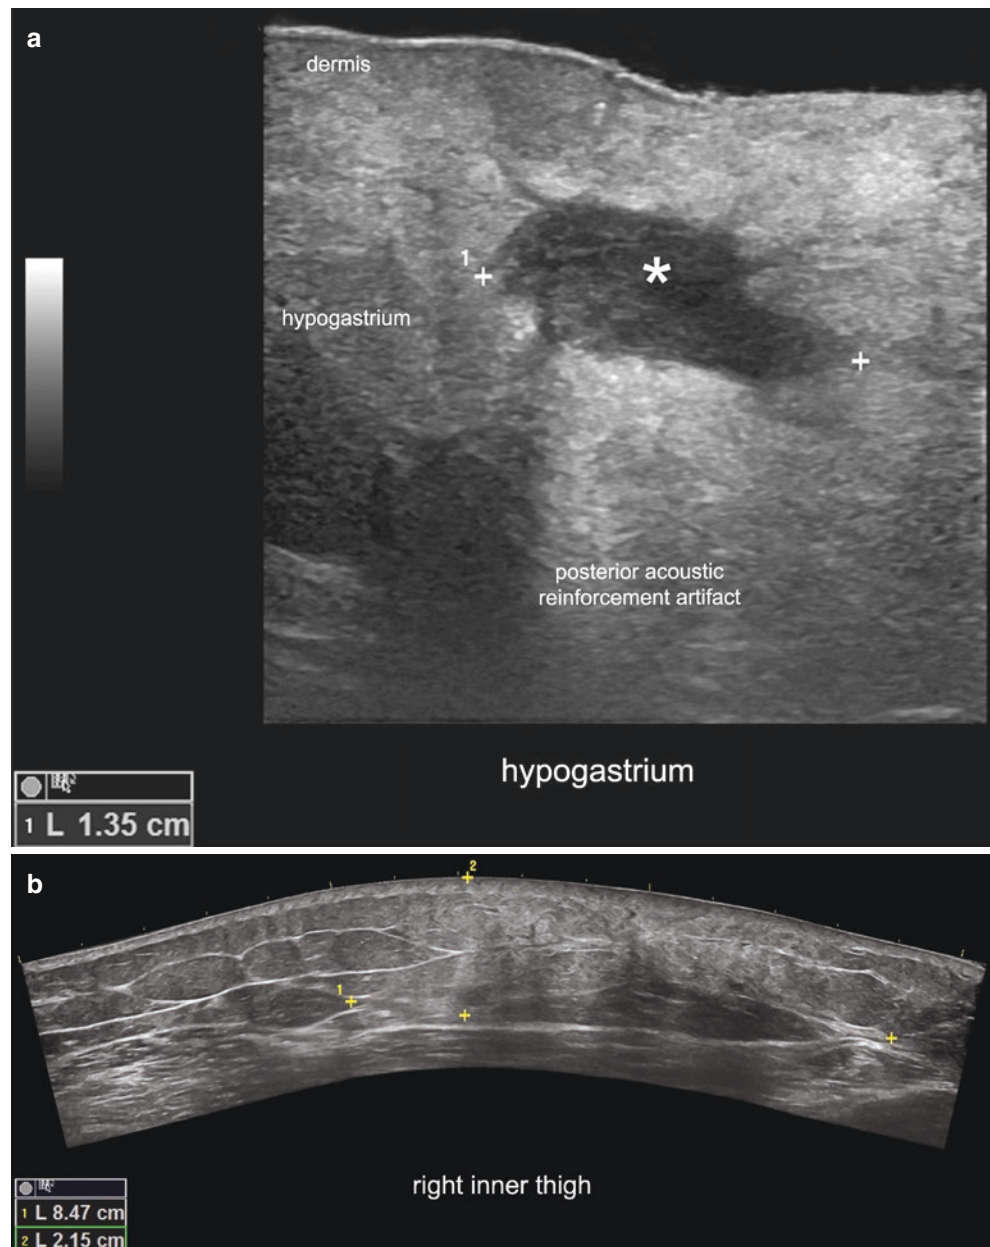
Liposuction. (a) Ultrasound (greyscale; longitudinal view; hypogastrium). Hypoechoic fluid hypodermal collection (*asterisk*) that corresponds to serohematoma, which produces posterior acoustic reinforcement. The echogenicity of the surrounding hypodermis is increased, and the dermis is thickened with decreased echogenicity owing to edema. (b) Ultrasound (greyscale; transverse view; inner aspect of the right thigh) shows a focal region that measures 8.47×2.15 cm and presents increased echogenicity of the hypodermis, with a few anechoic fluid bands. Notice that this region does not show the typical echostructure of the fatty tissue. (c) Color Doppler ultrasound (longitudinal view; inner aspect of the right thigh) demonstrates increased blood flow in the hypodermis due to inflammation.
